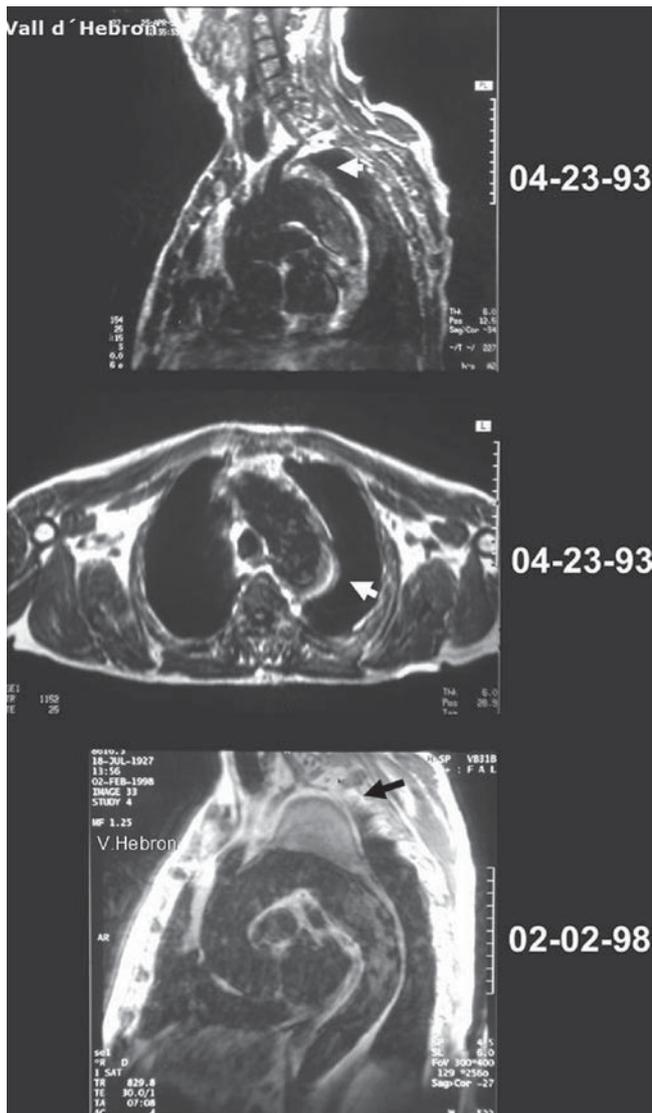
Penetrating atherosclerotic ulcer with small intra-mural haemorrhage located in the upper part of the descending aorta. T1-weighted, in sagittal (a) and transversal views (b), reveals this ulceration (arrows). (c) After 5 years of asymptomatic evolution, MRI shows a large saccular aneurysm formation (arrow). In the original site of the atherosclerotic ulcerated plaque
